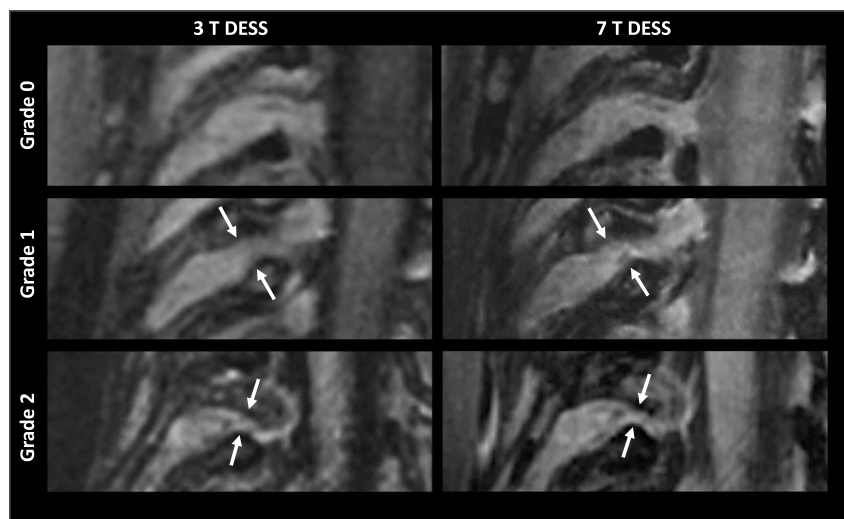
Nerve root compression grading at the level of the neuroforamen using 3D DESS MRI at 3 T and 7 T. Direct compression of cervical nerve roots was graded as follows: grade 0, no discernible morphological changes, normal nerve appearance; grade 1, slight to moderate compression of the nerve root, accounting for less than 50% of the nerve diameter (arrows); grade 2, severe compression or collapse of the nerve root, involving more than 50% of the nerve diameter (arrows). Note: Right cervical nerve roots from different patients are depicted in oblique coronal reconstructions of DESS images over the neuroforamen.
